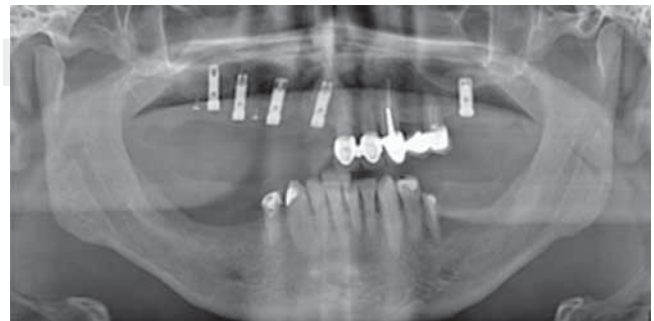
Panoramic x-ray with implants in place.
